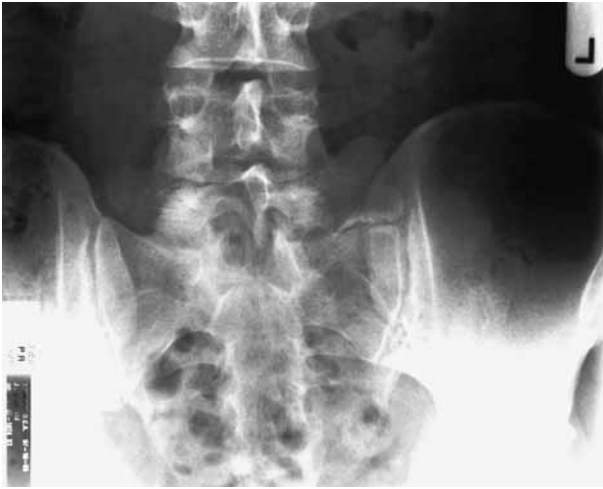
Plain A-P radiograph of a patient without low back pain and with a unilateral (left-sided) LSTV, type IIa according to Castellvi.
